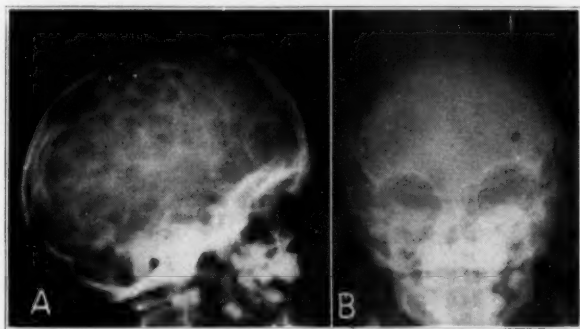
Roentgenograms revealing absence of suture lines. *A*, a lateral view, shows the typical thin skull with convolucional markings, due to prolonged increase in intracranial pressure. The middle fossa is deep; the auditory canal is low. All the sinuses are small; the maxilla is small, and the mandible is prognathous. There is marked bulging of the skull at the site of the anterior fontanel. *B*, an antero-posterior view, likewise shows the convolucional markings and the peculiar pointed or rooflike skull.
